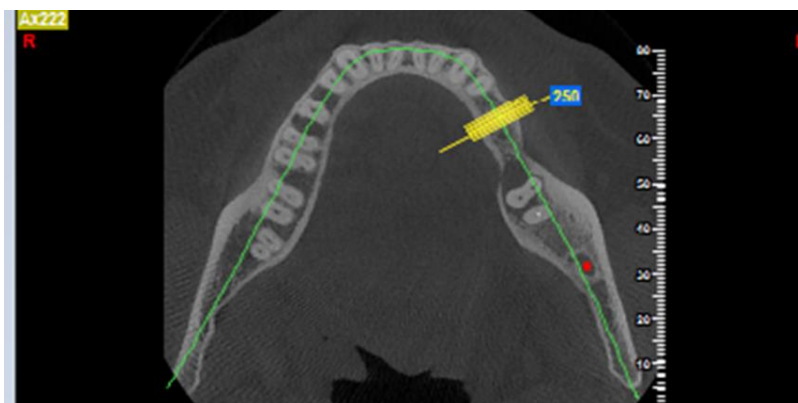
Axial CBCT image of tooth #20 with root canal treatment.
